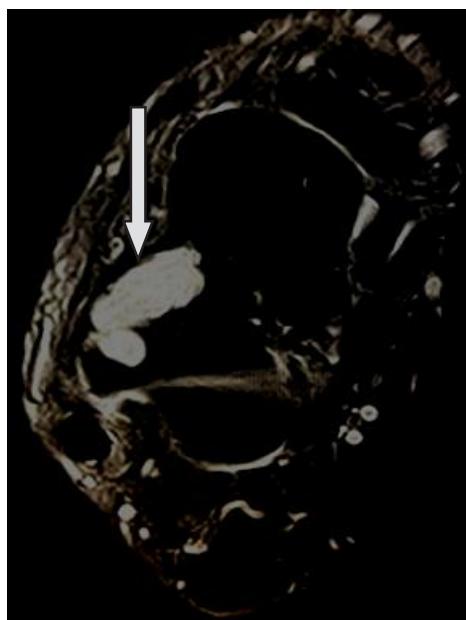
Proton density weighted MRI showing coronal view of right ankle with intermediate signal intensity lesion at talus (white arrow)
